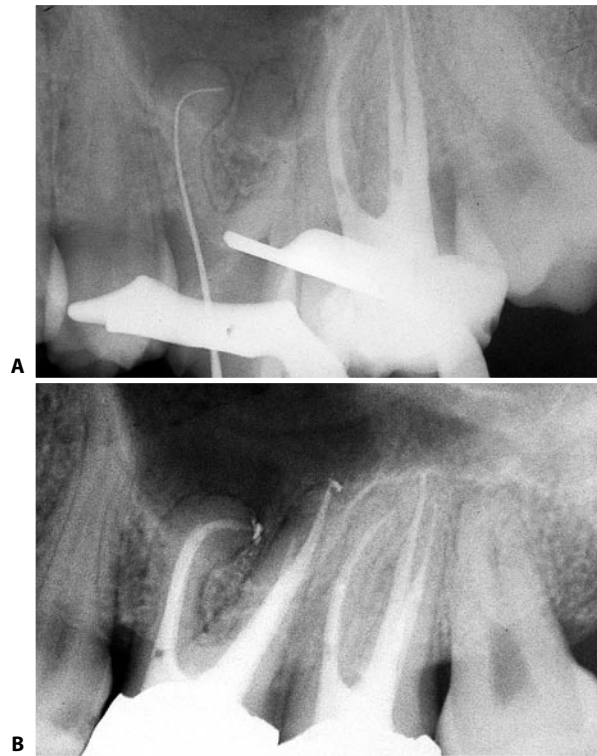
A. Radiograph checking the working length of the mesiobuccal canal. Note the considerable degree of curvature of the canal. B. Two year recall.
